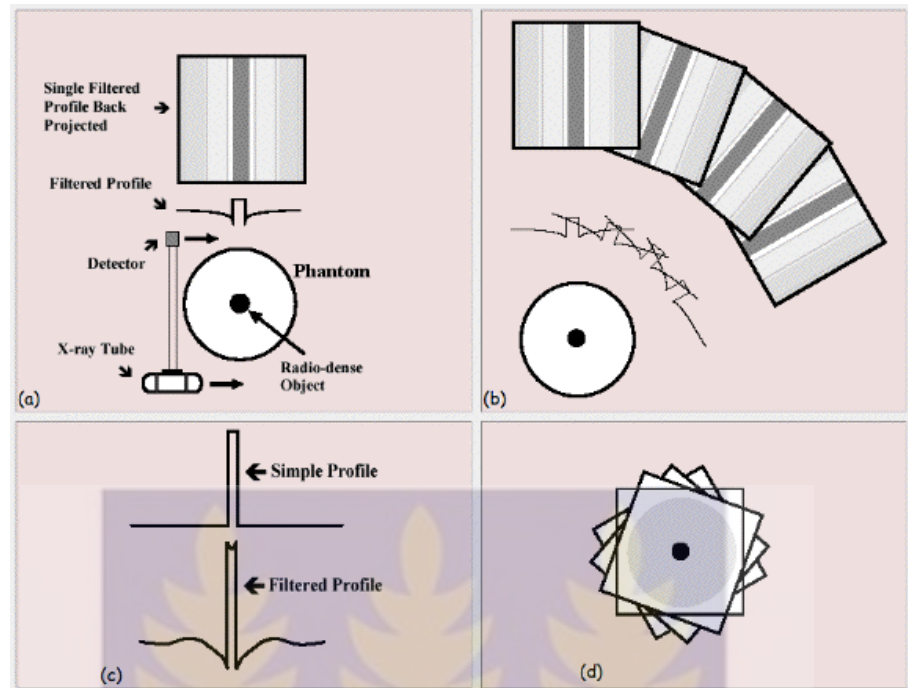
Filtered back projection: The views are filtered before back projection during the reconstruction of image. In mathematical basis, the end result is more accurate. This algorithm is the most commonly used algorithm when it comes to CT systems(Darvish, 2013).
